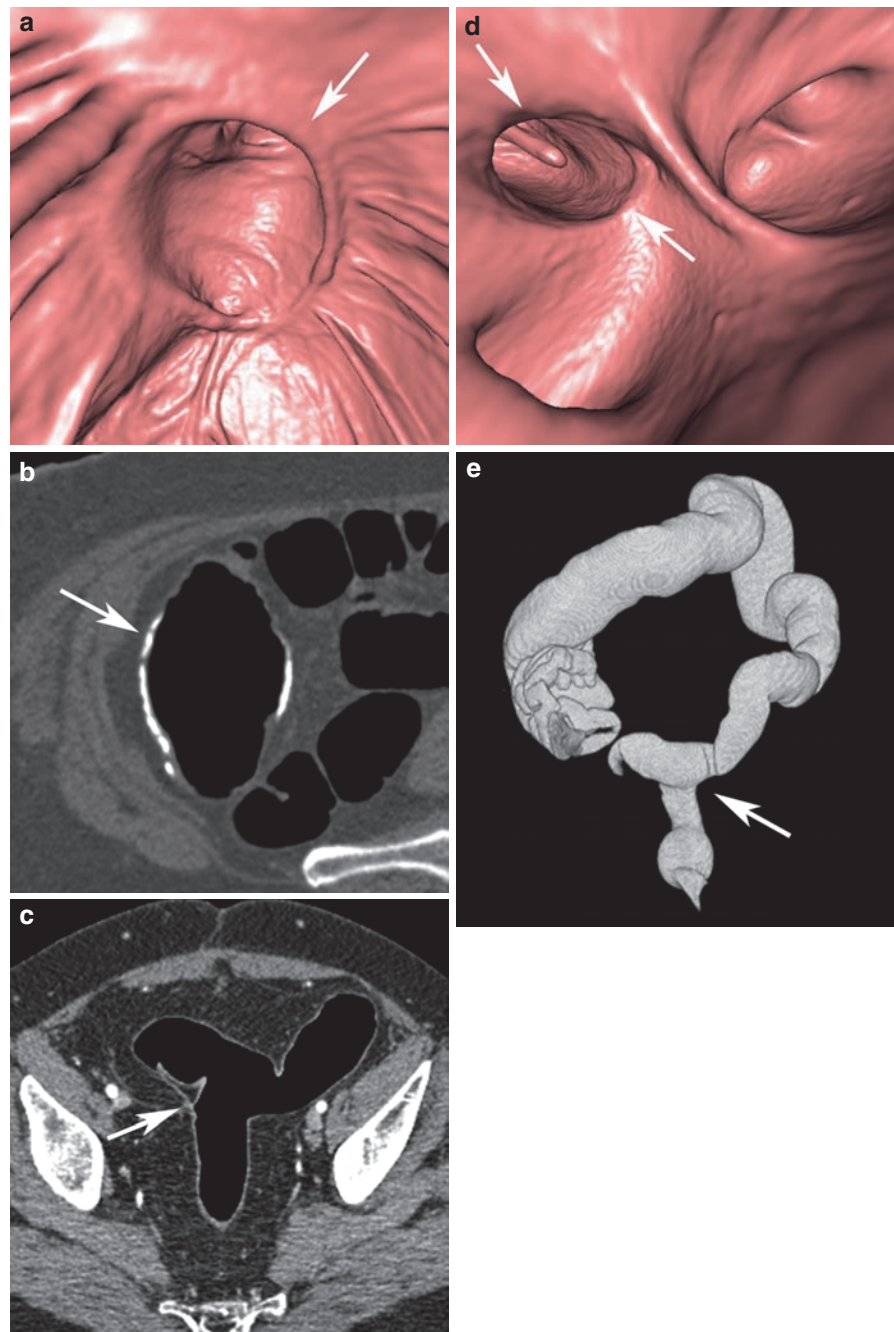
(a, b) Right hemicolectomy: CT colonography reveals a second (metachronous) cancer in the transverse colon (*arrow*) and a cancer recurrence at the entero-colic anastomosis (*arrowhead*), which was not diagnosed by endoscopy
